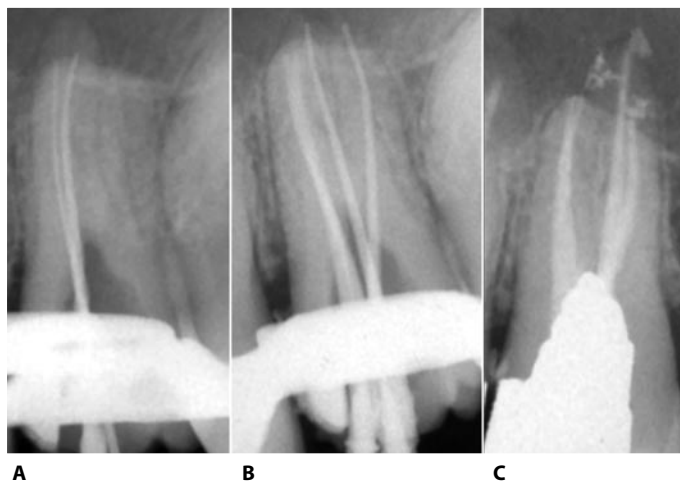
Endodontic treatment of an upper left second molar. A. Working length determination in the two mesio buccal canals. B. Plastic verifiers radiograph. C. Post-operative radiograph with a large lateral canal associated with the palatal root.
